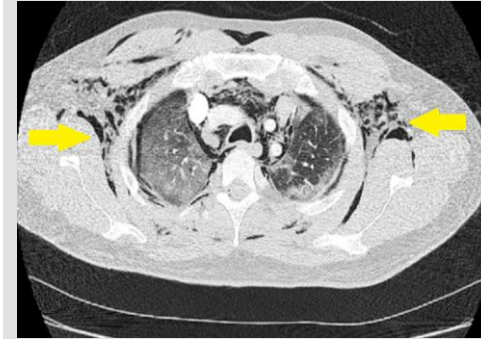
(top) and 2 (bottom) Chest CT axial sections of pulmonary parenchymal window showing extensive ground glass opacities in both lung fields, along with subcutaneous emphysema (yellow arrows), and pneumomediastinum (red arrows).
